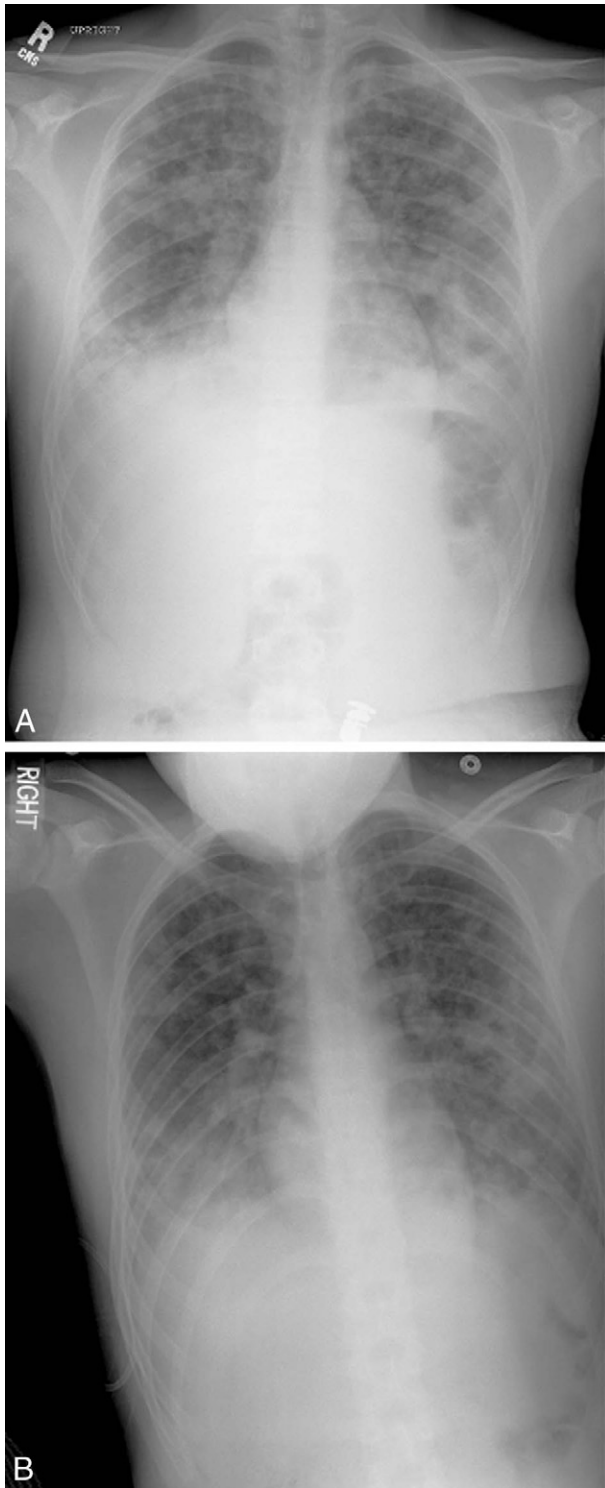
Panel A, Chest radiograph of a 15-year-old male with high-altitude pulmonary edema after helicopter evacuation from an altitude of 11 000 feet (3353 m) to 4500 feet (1372 m). The chest radiograph shows dense bilateral patchy alveolar infiltrative change and normal cardiac and mediastinal width. Panel B, Chest radiograph from the same patient after
